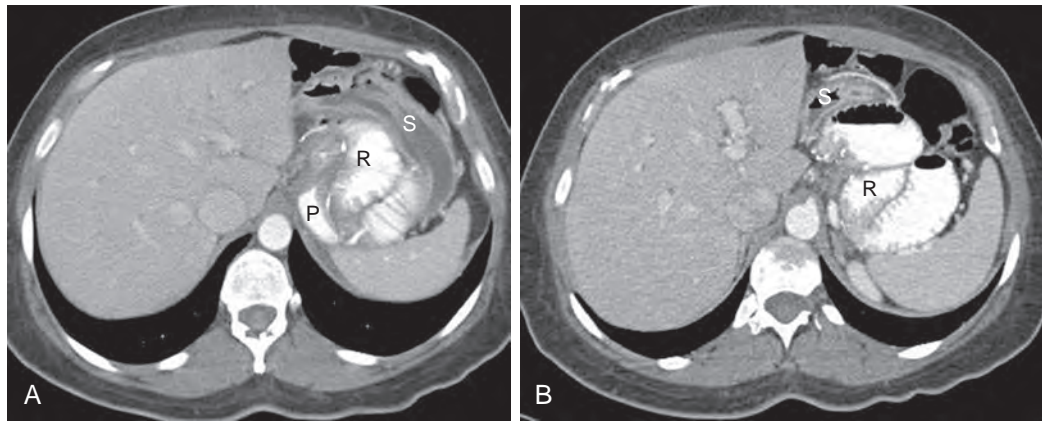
Internal hernia following RYGB on CT. A, B. Axial CT images following positive oral and IV contrast show RYGB anatomy with the Roux limb (R) clustered, dilated, and displaced cephalad to the pouch (P) and compressing the excluded stomach (S) secondary to an internal hernia. The JJ suture line was also displaced cephalad (not shown).
